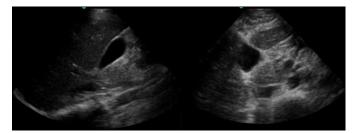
Gallbladder ultrasound without signs of cholelithiasis or biliary sludge, with normal appearance and size of common bile duct (2 mm).
